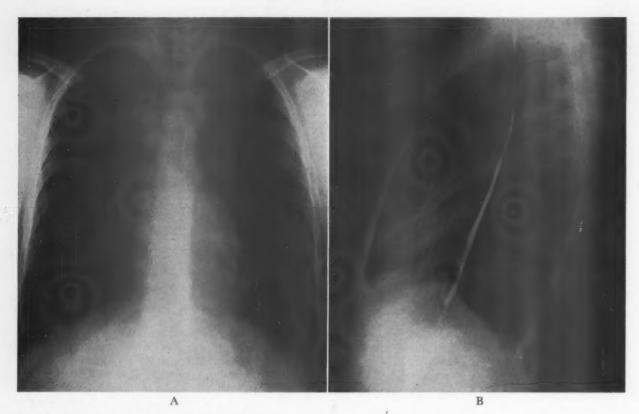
Posteroanterior (A) and left lateral (B) roentgenograms of the chest. Note the absence of left atrial enlargement.
